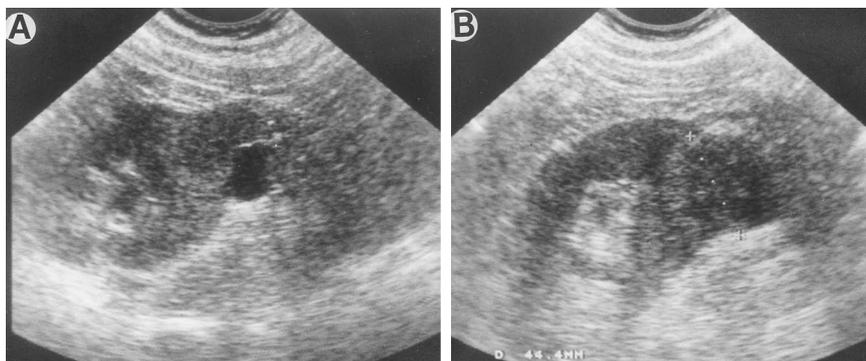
Ultrasound. A, 3.8 cm. solid lesion with internal cystic component in lower pole of left kidney in February 1991. B, 4.4 cm. tumor in March 1993.
